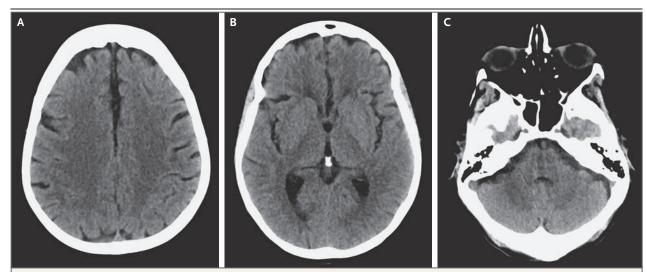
Initial CT of the Head.
